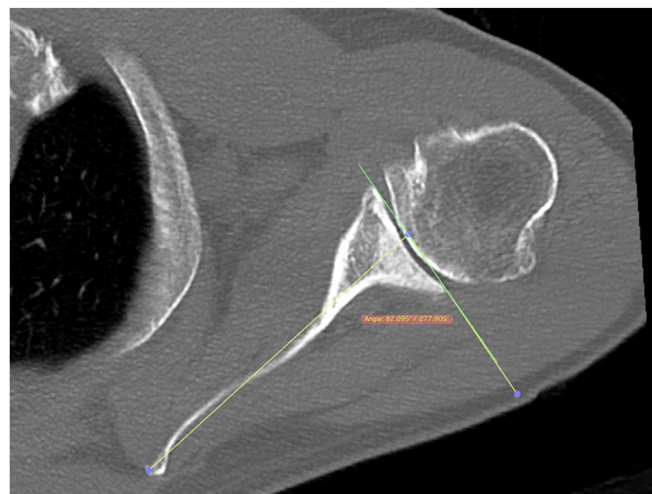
Axial slice of a fine-cut CT scan in a 68-year-old female patient demonstrating mild biconcavity of the glenoid and loss of joint space consistent with primary glenohumeral osteoarthritis. Friedman's line is drawn to calculate glenoid version, which, in this patient is 8° of glenoid retroversion. CT, computed tomography.
